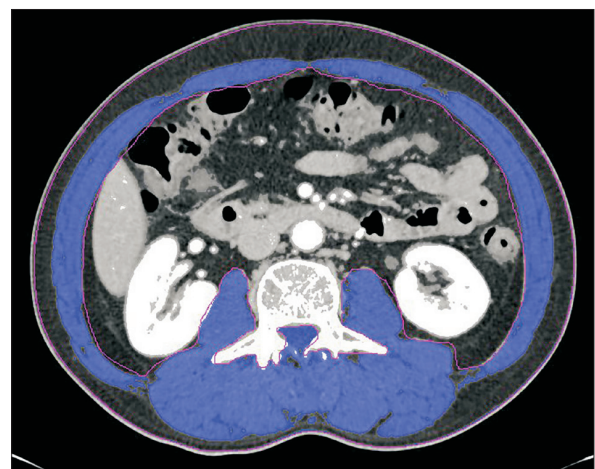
Measurement of the skeletal muscle. Axial computed tomography obtained at the level of the third lumbar vertebra showing the region colored blue represent the skeletal muscle area.
